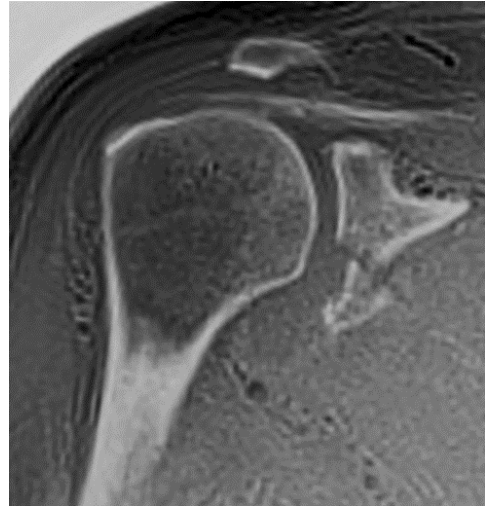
Coronal 3D-Bone shoulder MRI in a patient with recurrent shoulder dislocations shows a large displaced bony Bankart fragment from the anterior glenoid rim.
